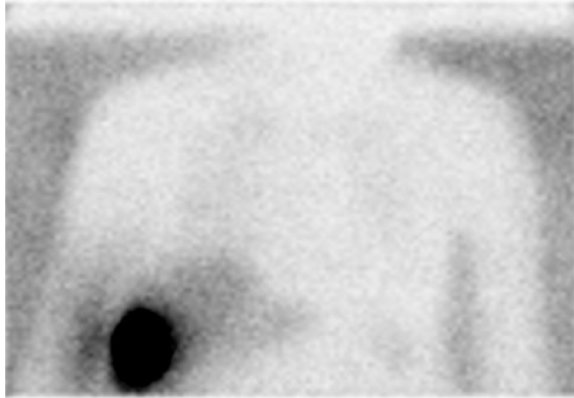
CT PET 1 hour post second injection of Tc-99M: melanoma on right flank.
